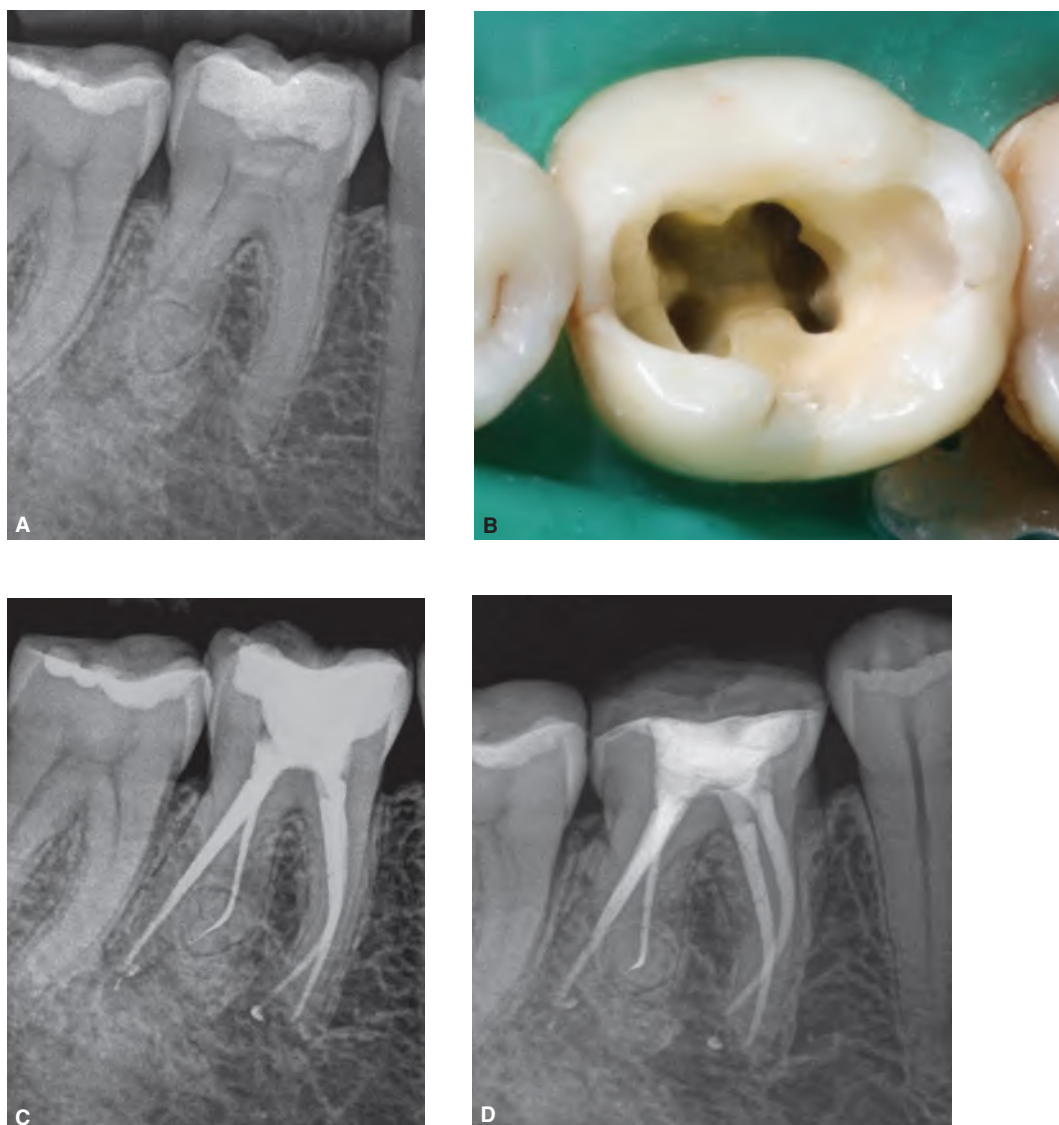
Radix entomolaris in a mandibular first molar of a 52-year-old female. Patient complained of spontaneous pain associated with the tooth. A. Preoperative radiograph showing presence of additional root. B. Clinical view of the access cavity showing two mesial canal orifices and three distal orifices. C. Immediate postoperative radiograph. D. One-year recall radiograph. The patient is asymptomatic and the tooth restored to function. (Courtesy of Dr. Francesc Abella, Barcelona, Spain. Adapted with permission from Abella, et al.²¹⁹)
